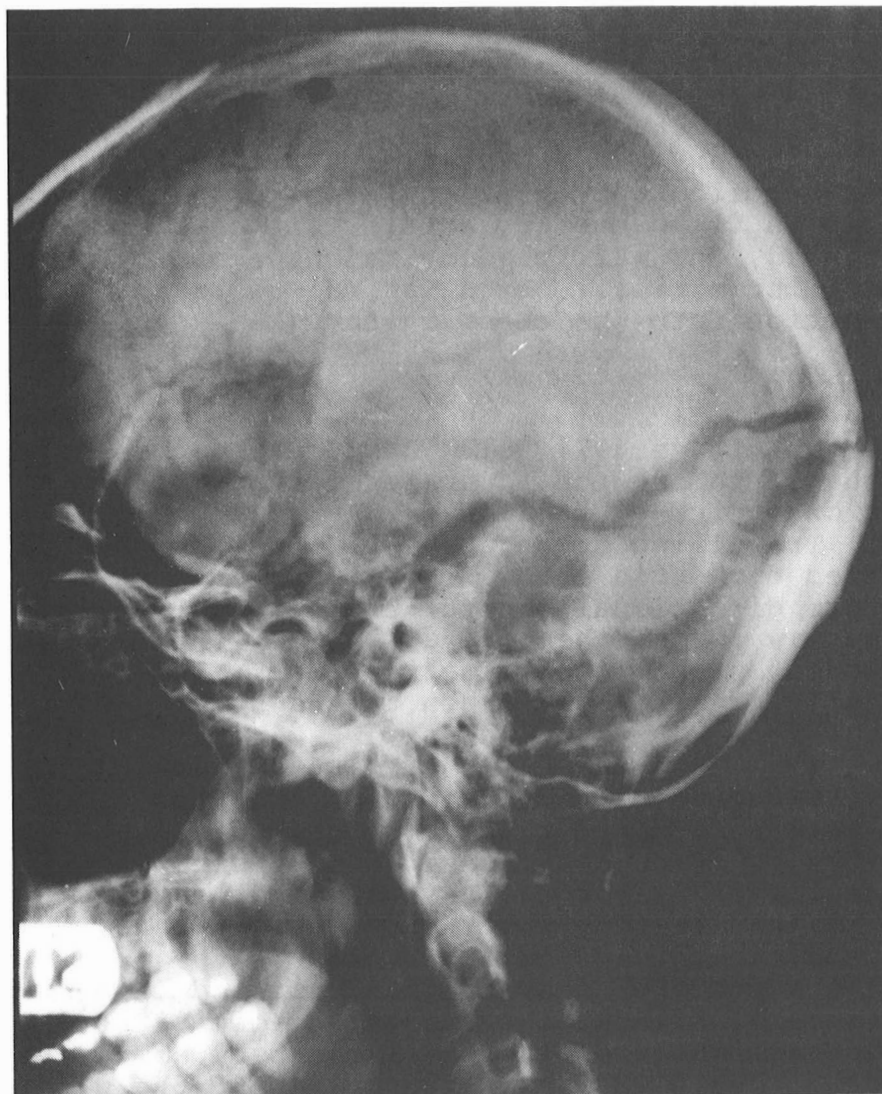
Radiograph showing lateral view of the bilateral basal and bi-occipital skull fracture to the driver in Case Study No. 2
